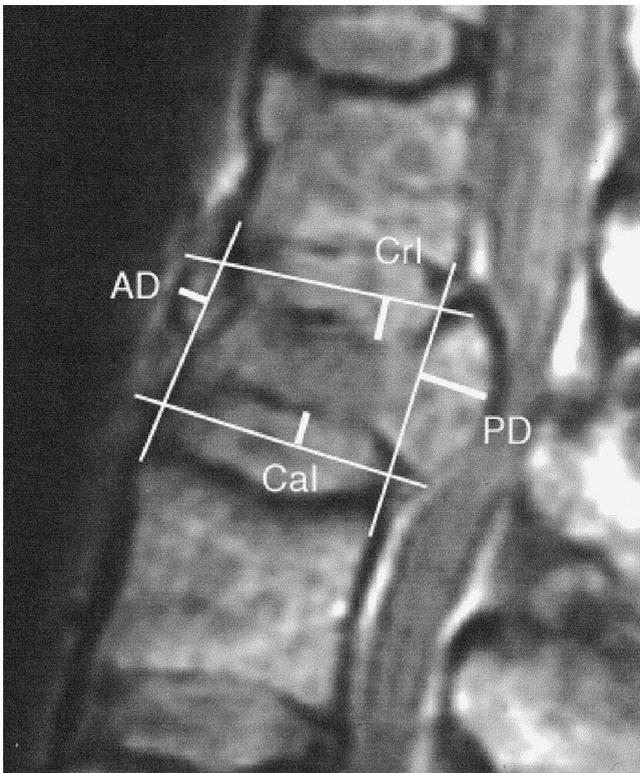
Graphical representation of the method used for assessing anterior displacement (AD), posterior displacement (PD), cranial impression (CrI), and caudal impression (CaI) projected on an MR image of a vertebral fracture.
